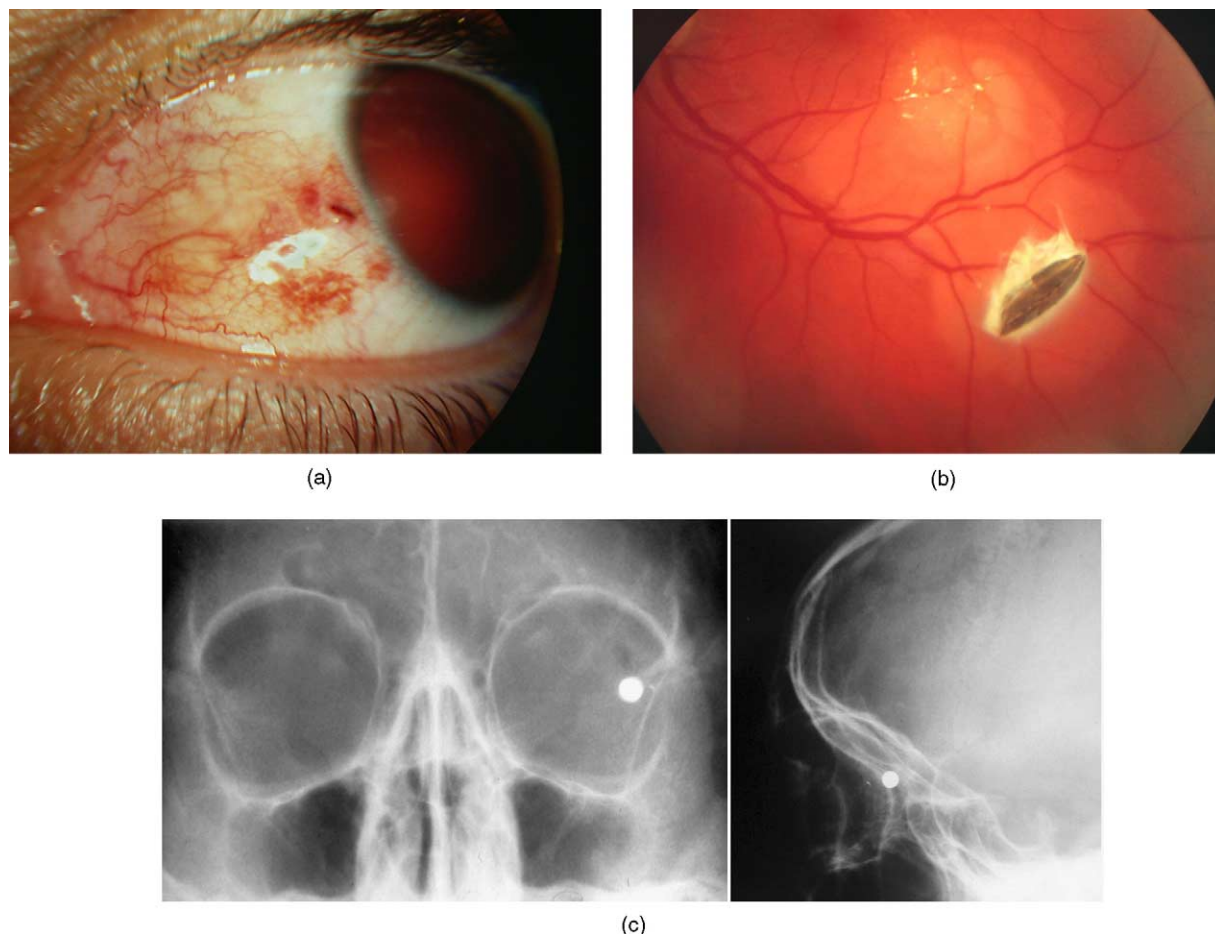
(a) Minute entry wound belies the severity of this open globe injury. (b) An intra-ocular foreign body. (c) X-rays of an intra-ocular foreign body.
